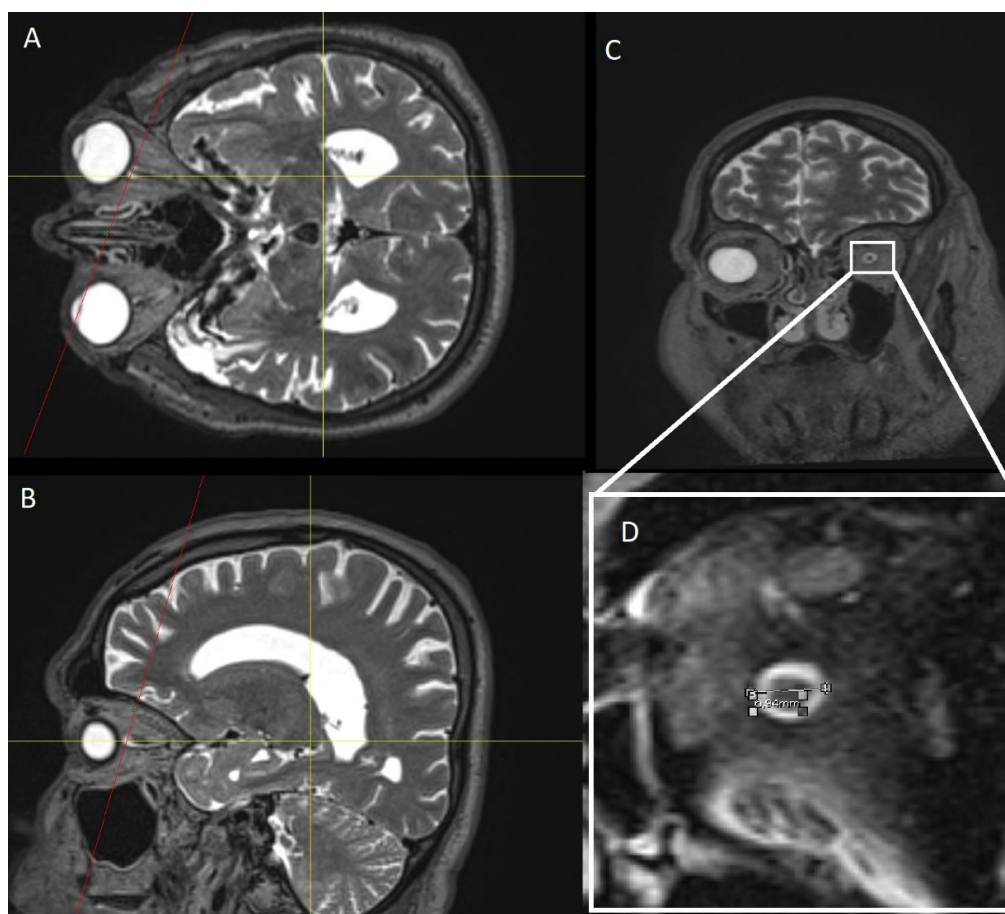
Evaluation of the optic nerve sheath complex reformatted in axial and sagittal T2 weighted images (A and B). T2-weighted image perpendicular to the left optic nerve sheath complex (C). Left optic nerve sheath complex measurement from the magnified image (D).
